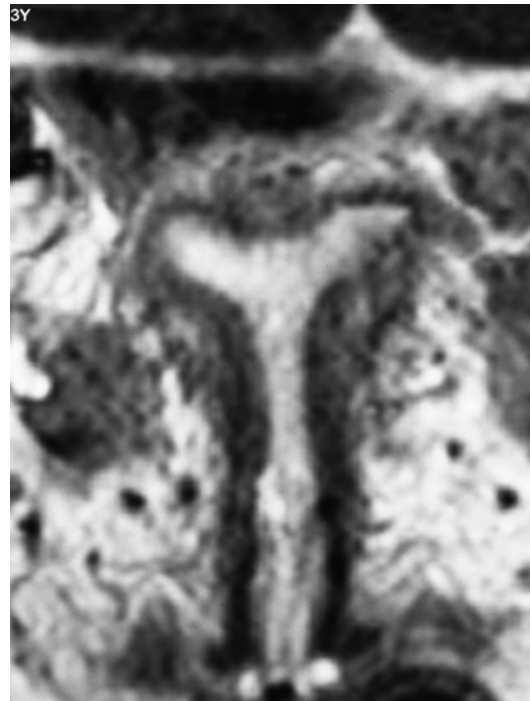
MRI image of a uterus infantilis (ESHRE/ESGE Class U1b)
